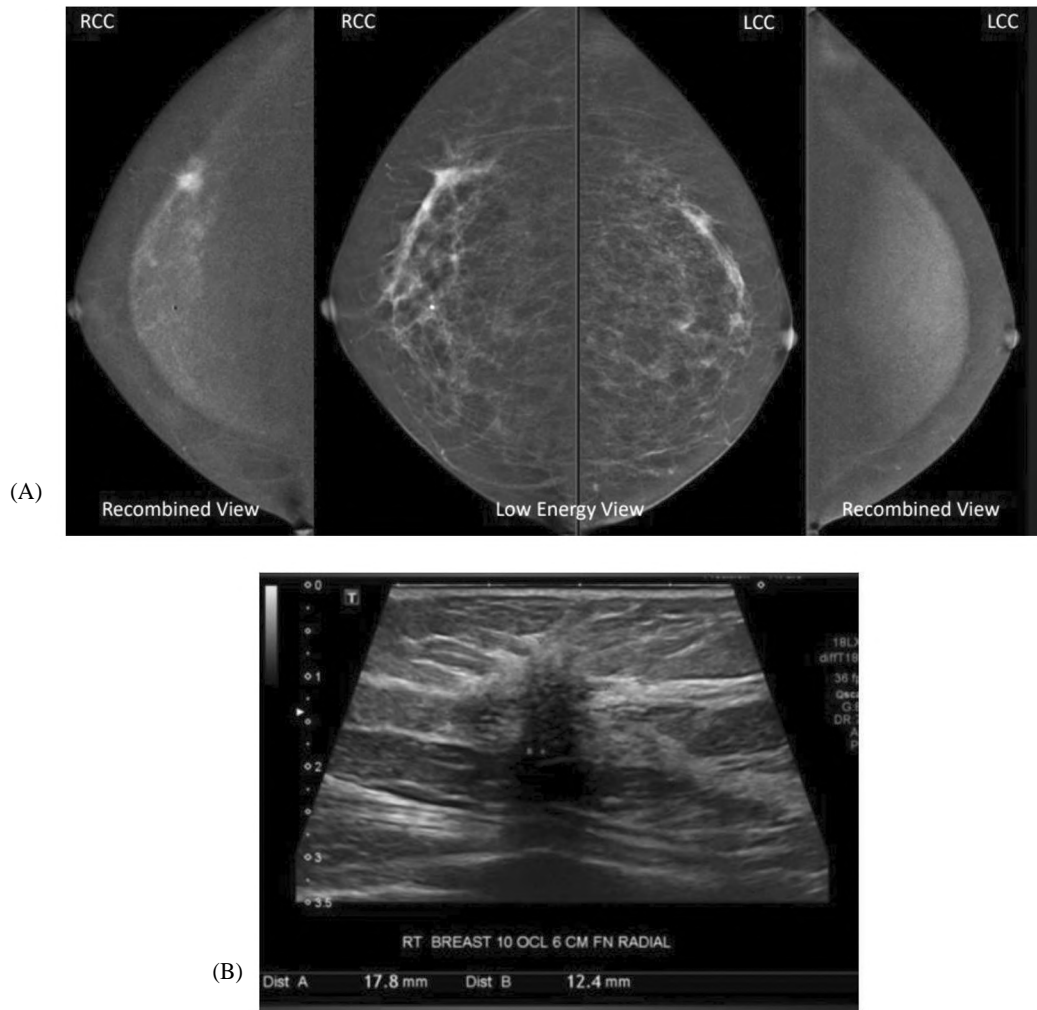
66-year-old female recalled for right breast focal distortion. (A) CESM & digital mammography views of both breasts showed dominant spiculated enhancing mass as well as non-mass enhancement medial and inferior spanning up to 4.5 cm. (B) Ultrasound showed ill-defined hypoechoic mass with posterior shadowing.
